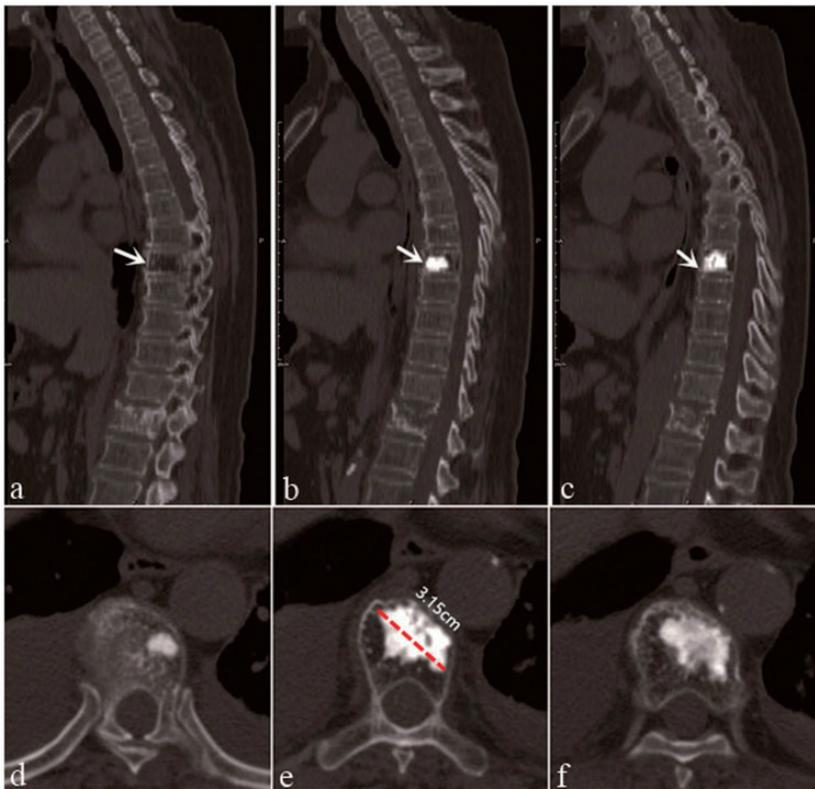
Computed tomography (CT) images. a–e: Low-density shadows combined with high- and uniform-density shadows on sagittal and cross sectional views, which differs from bone metastases, which show bone formation within soft tissue density; e: maximum diameter: 3.15 m.
